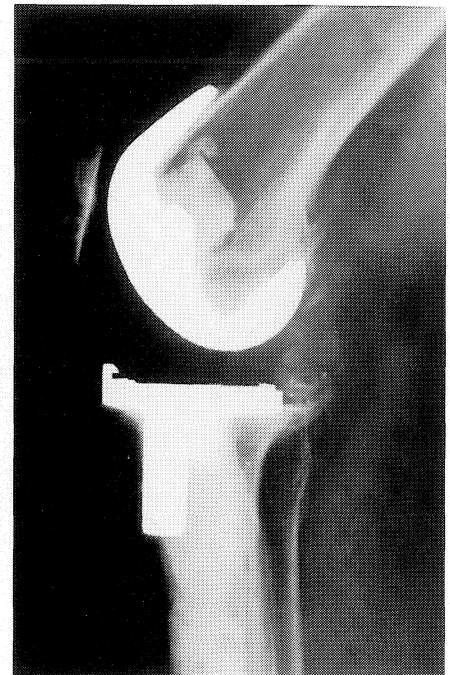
Lateral radiograph after revision arthroplasty with a posterior stabilized prosthesis.
